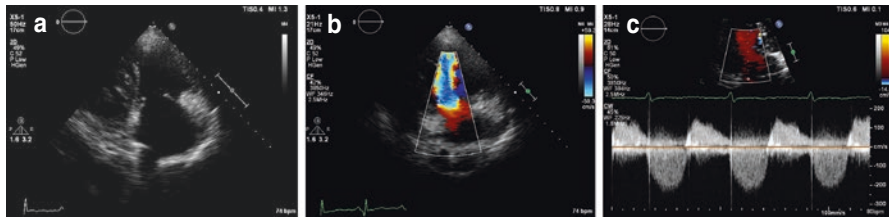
Example of a stenotic tricuspid valve on 2D-TTE (a); flow acceleration on colour-Doppler (b) and typical pattern on spectral continuous-wave Doppler (c)
